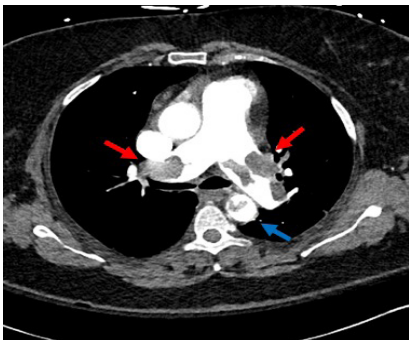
Axial View of CTA Showing Clot Burden in the both Main Pulmonary Arteries (red arrows). There is also Evidence of Clot in the Descending Aorta (Blue Arrow).
